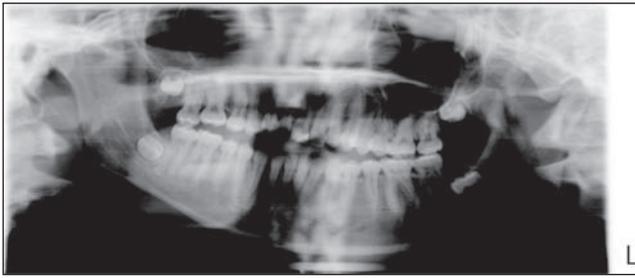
Orthopantomogram at the age of 13 years showed the presence of all permanent teeth along with the tooth buds of the 3<sup>rd</sup> molars.
